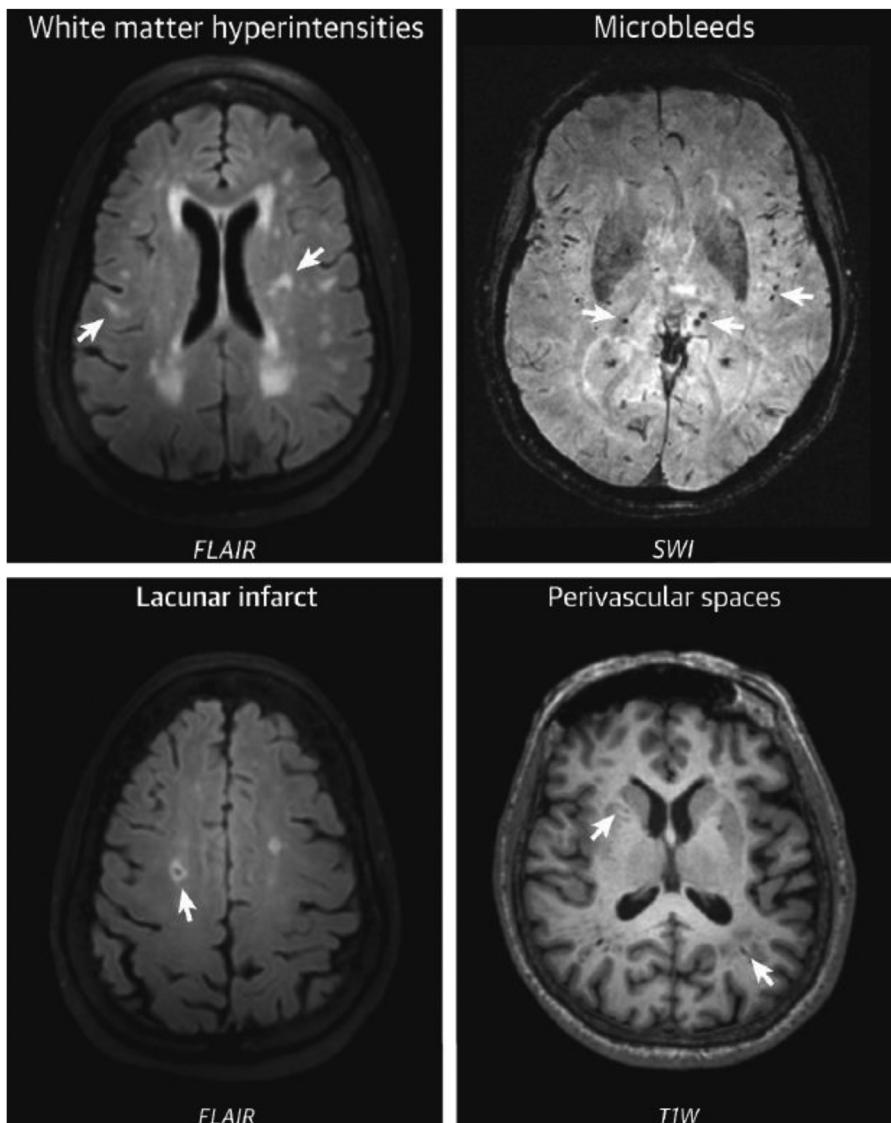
Examples of Cerebral Small Vessel Disease on Brain MRI. Arrows indicate the presence of white matter hyperintensities, microbleeds, lacunar infarcts, and perivascular spaces. FLAIR, fluid attenuation inversion recovery; SWI, susceptibility-weighted imaging; T1W, T1 weighted. (From Amier RP, Marcks N, Hooghiemstra AM, et al. Hypertensive Exposure Markers by MRI in Relation to Cerebral Small Vessel Disease and Cognitive Impairment. *JACC: Cardiovascular Imaging*. 2021;14(1):176-185. <https://doi.org/10.1016/j.jcmg.2020.06.040>; with permission.)
